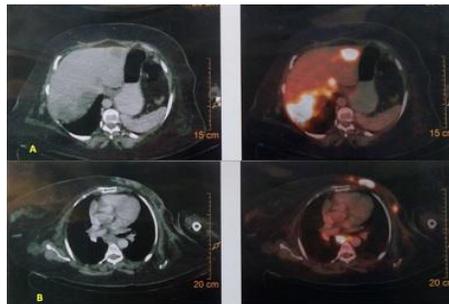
FDG PET Image (A) Showing multiple metastatic lesions in the liver (B) Showing uptake over the left chest wall and left axilla
